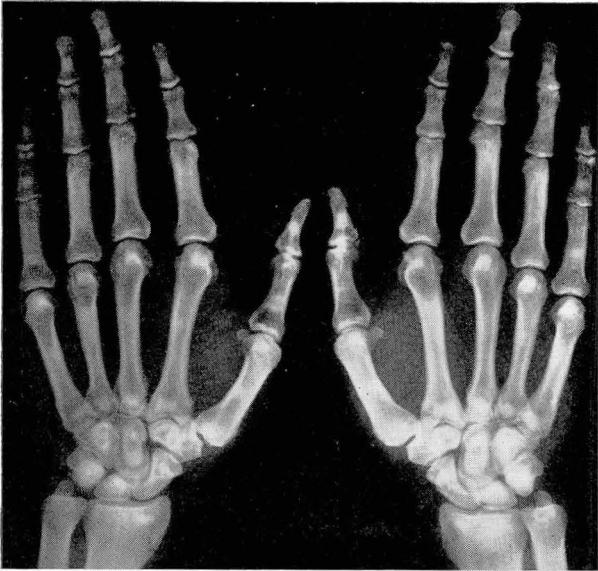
Roentgenogram of the hands showing the "bone within a bone" appearance of the carpal bones.
